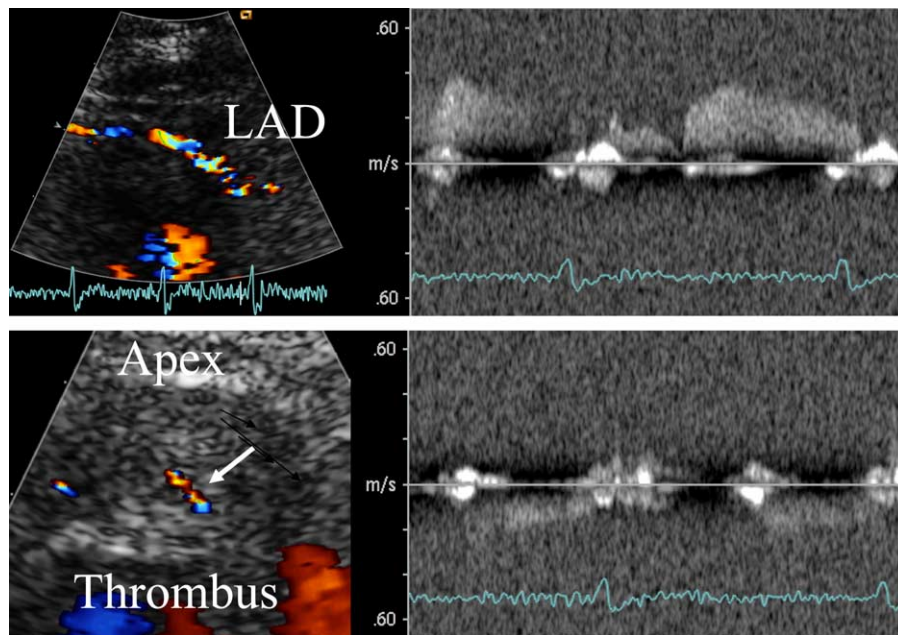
Transthoracic coronary Doppler ultrasound shows a vessel penetrating from the endocardium into an apical thrombus (arrow), indicating that the lesion is not recent. The direction of flow in the neo-vessel is opposite to the transducer, whereas in the LAD it is directed towards the transducer.
